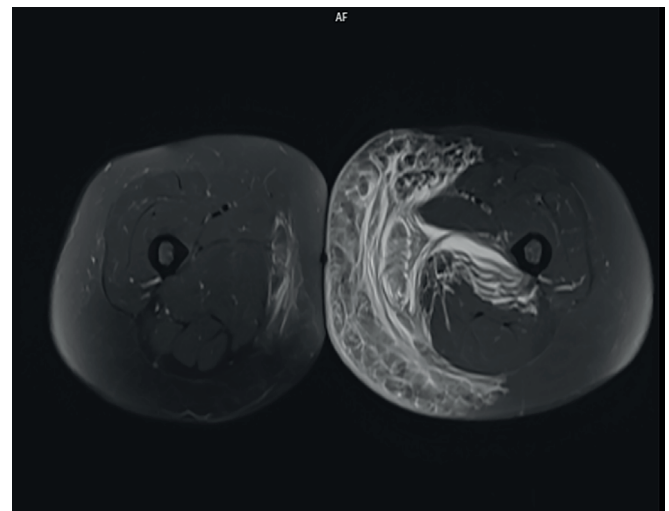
Radiological appearance of an organized hematoma on MRI
